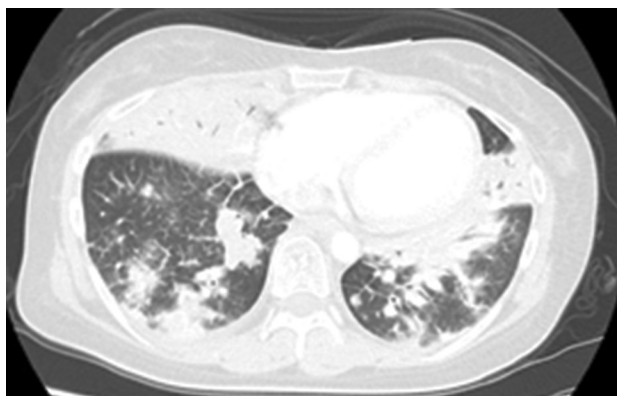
Computed tomography scan of the patient before death
